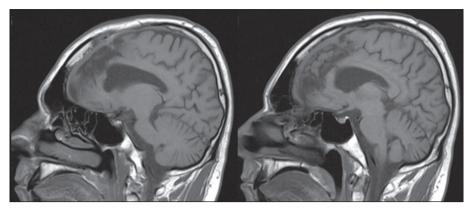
Post-resection MRI in T1 sequence; resection of the mesial prefrontal cortex and anterior and middle cingulum, with the SMA as the posterior limit.
